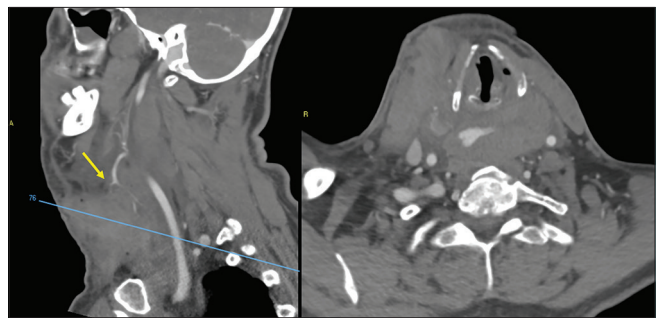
Sagittal (left) and axial (right) CT angiography scan sequences showing a grown up hematoma a few minutes away, the yellow arrow indicates the origin of the bleeding from the right superior thyroid artery.
